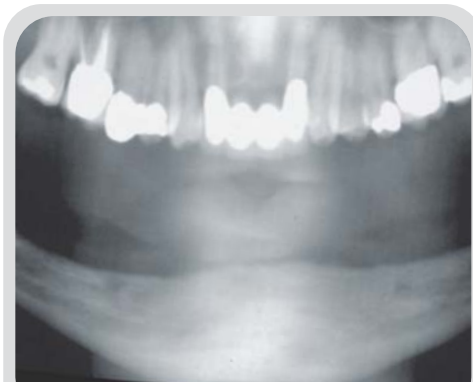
Case 1. Panoramic radiograph of patient's edentulous mandible prior to implant placement.
